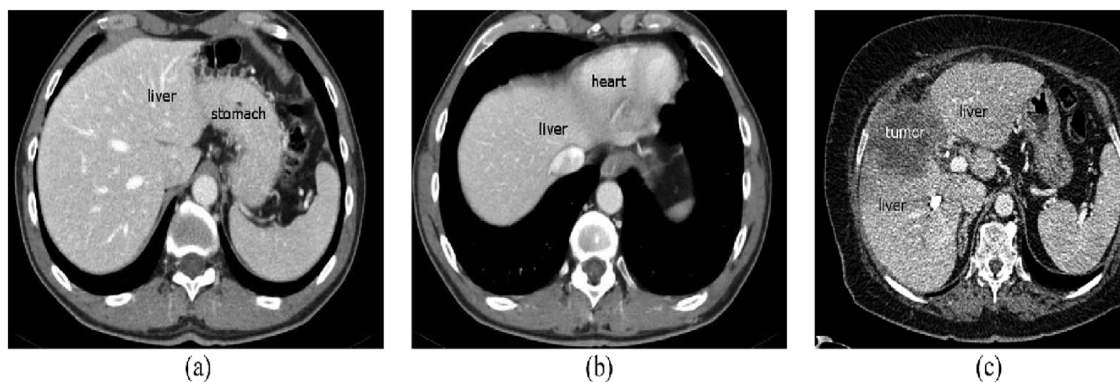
Abdominal liver CT axial section, shows the liver nearby, same intensity and connected to other organs.
